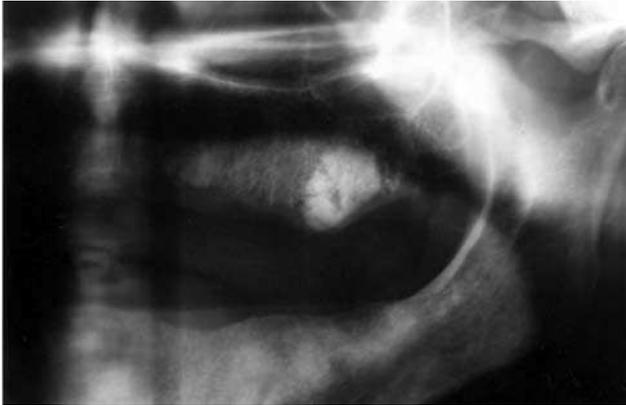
Panoramic radiograph of the patient, showing the lesion in the body of the left part of the maxilla
